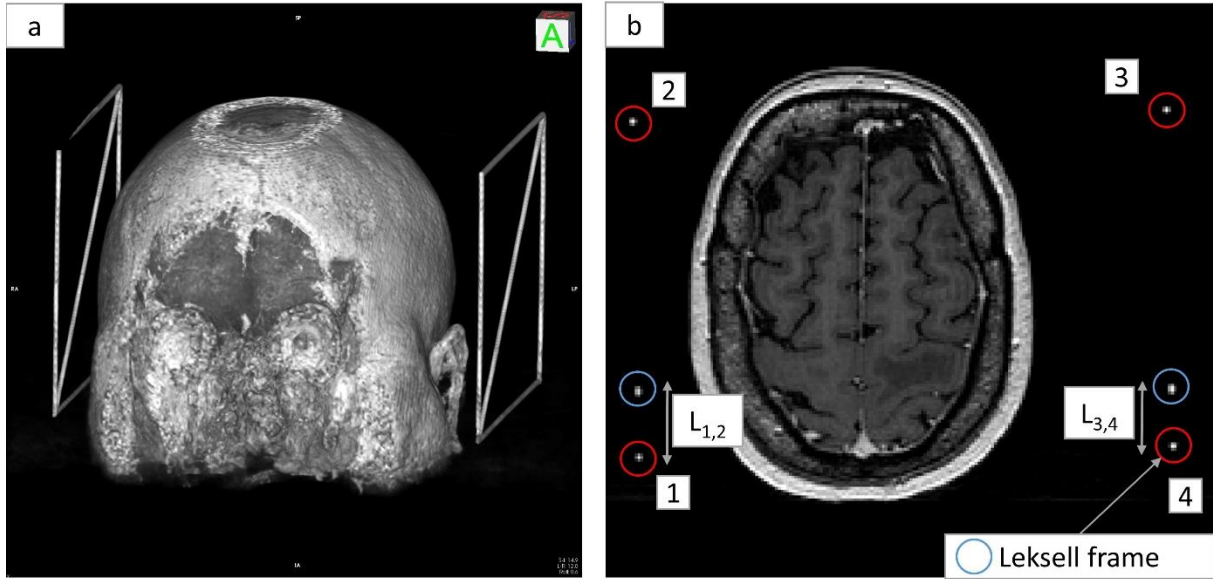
a) 3D rendering showing the Leksell frame to the left and right side of the patient's head. b) MRI exams showing the six dots (enclosed in circles) matching the 6 radio-opaque rods included inside the Leksell frame.
